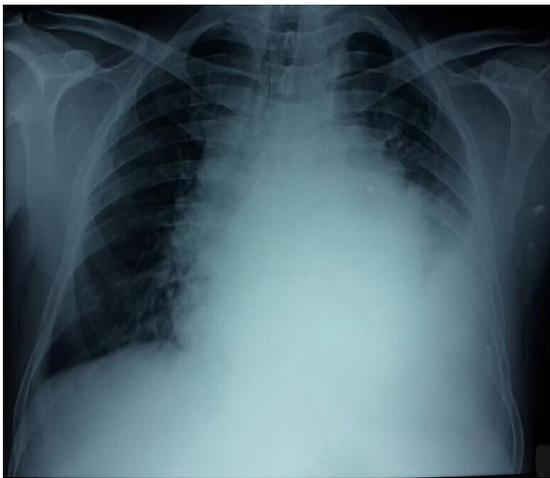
X-Ray chest shows mediastinal widening with left sided pleural effusion
